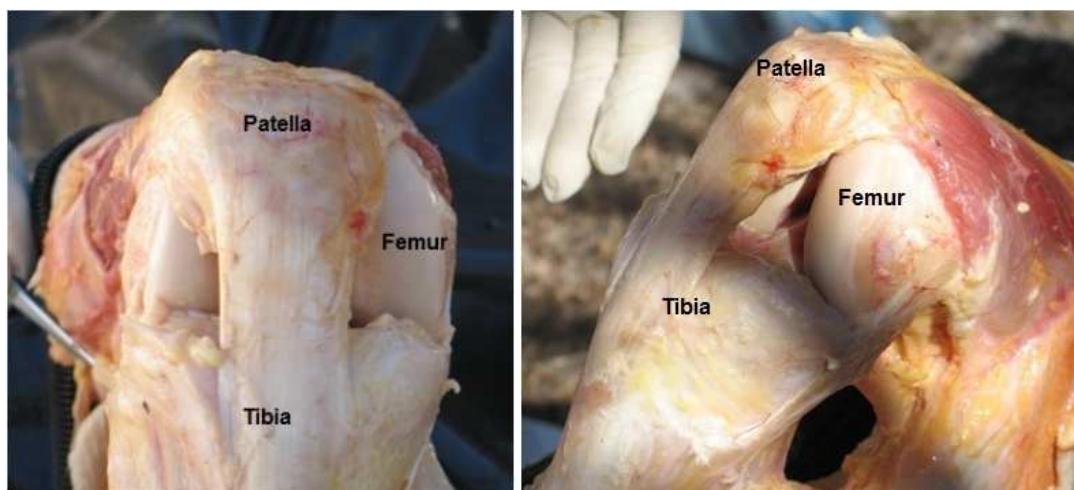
Dissected cadaver's knee showing the different ultrasound-visible regions of the patella, distal femur, and proximal tibia at 90 degrees flexion
